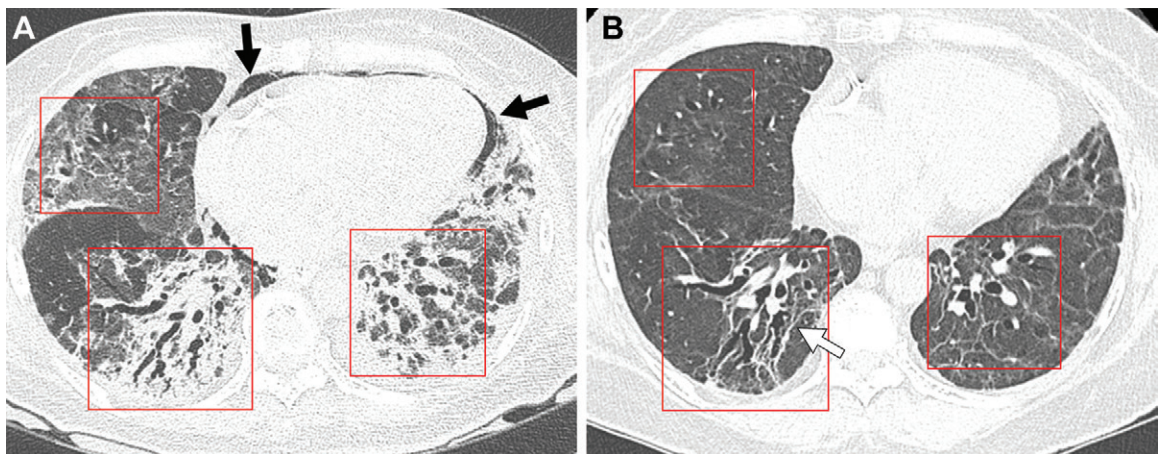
Serial images in a 64-year-old woman with COVID-19 pneumonia. (A) Transverse nonenhanced CT scan (lung window) obtained at ventricular level 1 month after SARS-CoV-2 infection shows lower-lobe-predominant patchy and wide areas of mixed consolidation and ground-glass opacity (GGO) in bilateral lungs. Note areas of bronchial dilatation (boxes) within parenchymal lesions. Pneumomediastinum (arrows) is also present anteriorly. (B) Transverse nonenhanced CT scan (lung window) obtained 12 months after infection demonstrates dilated bronchi (boxes) within remaining GGO lesions. Linear parenchymal bands (arrow) are also noted.
